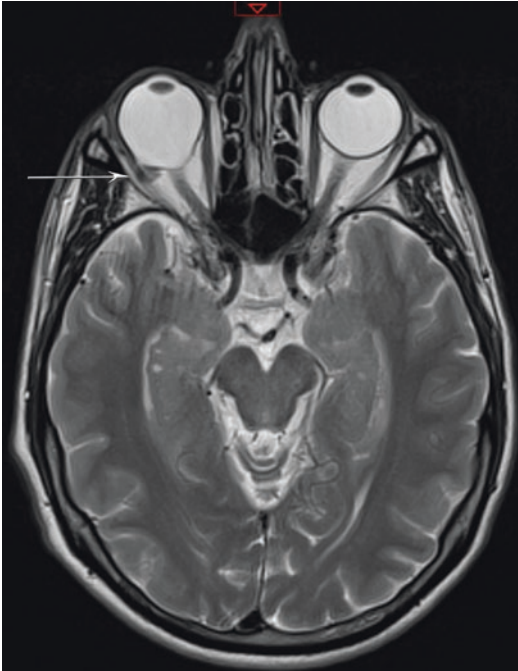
MRI of a patient operated with macular buckle. The right eye is highly myopic and the section of the buckle is indicated by the white arrow
